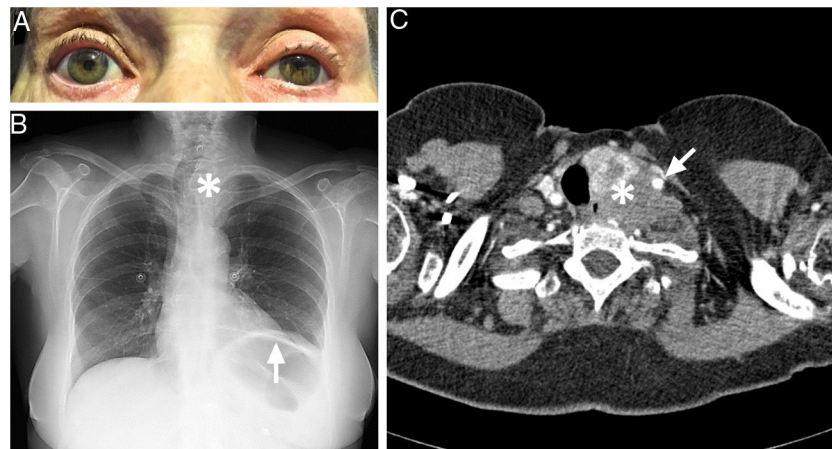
(A) Left ptosis and miosis in semi-darkness. (B) Anteroposterior chest radiography showing elevation of the left hemidiaphragm (arrow) and right-sided tracheal deviation in the superior mediastinum (asterisk). (C) Neck CT scan (axial plane) with intravenous contrast, revealing a mass originating from the left thyroid lobule (asterisk), with irregular density and involving the left common carotid artery (arrow).
